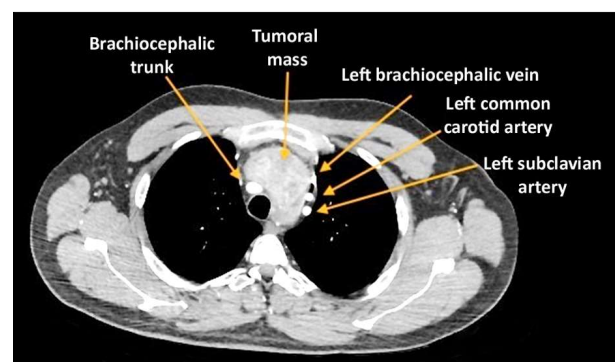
CT view of lesion and surrounding anatomy
